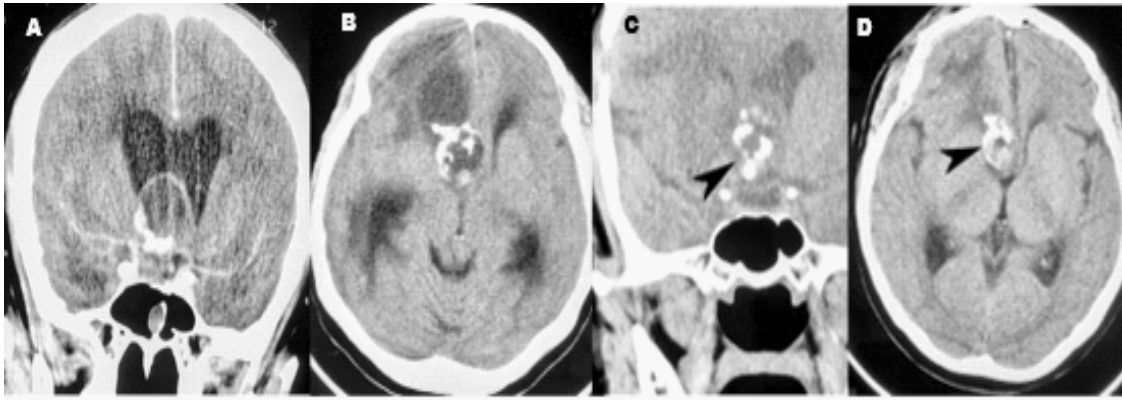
Preoperative enhanced coronal (A) and axial (B) CT scans revealed a calcified tumor in the anterior third ventricle, with obstructive hydrocephalus. Initial postoperative coronal (C) and axial (D) CT scans showed partial tumor resection via a right frenotomy. The arrowhead points to the tumor.
